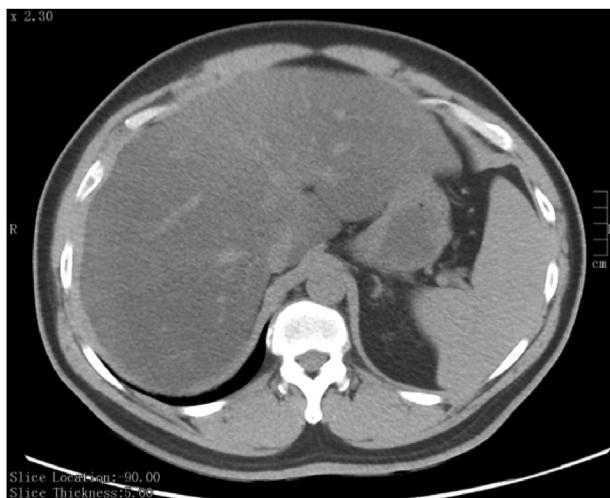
CT image showing the fatty changes in the liver.
